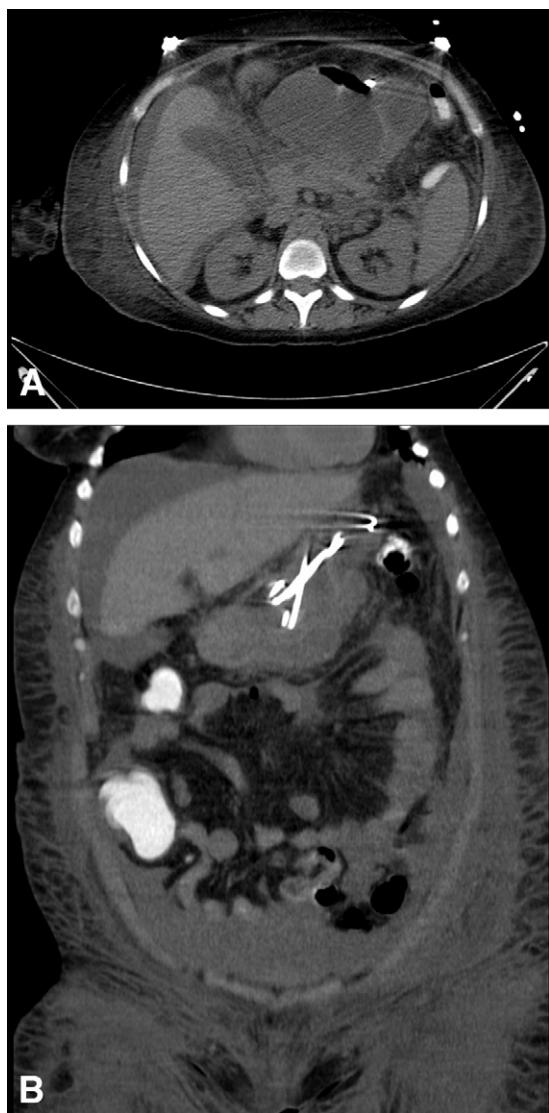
A, A CT of the abdomen revealing a large walled-off pancreatic necrosis. B, After drainage by the multiple transluminal gateway technique, a CT of the abdomen at 72 hours reveals marked resolution in size of the walled-off pancreatic necrosis. The multiple stents are better visualized on a coronal view.
